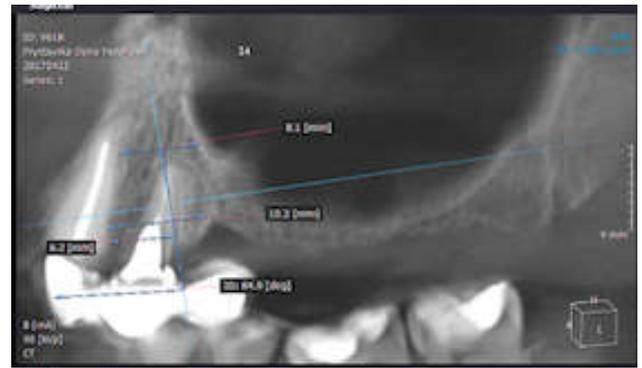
CT image, patient P., 1970. Diagnosis: "Periodontitis 24. Partial adentia of the distal upper jaw on the left side"
